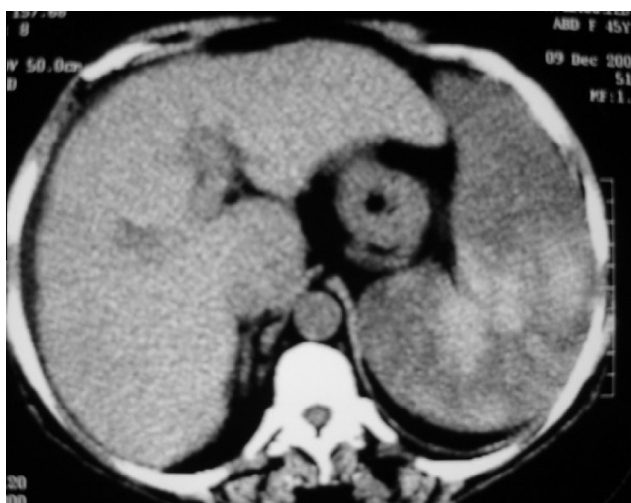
Unenhanced CT scan 1 week after the 2nd session showing extensive splenic infarction counting for about 80%.
